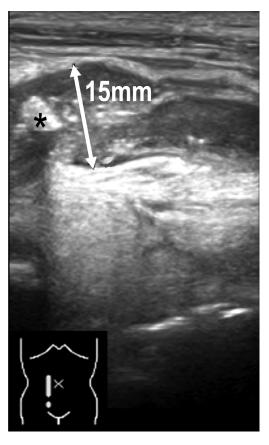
Abdominal ultrasonography shows a swollen appendix with fecal stone (asterisk): well compatible with a diagnosis of acute appendicitis
